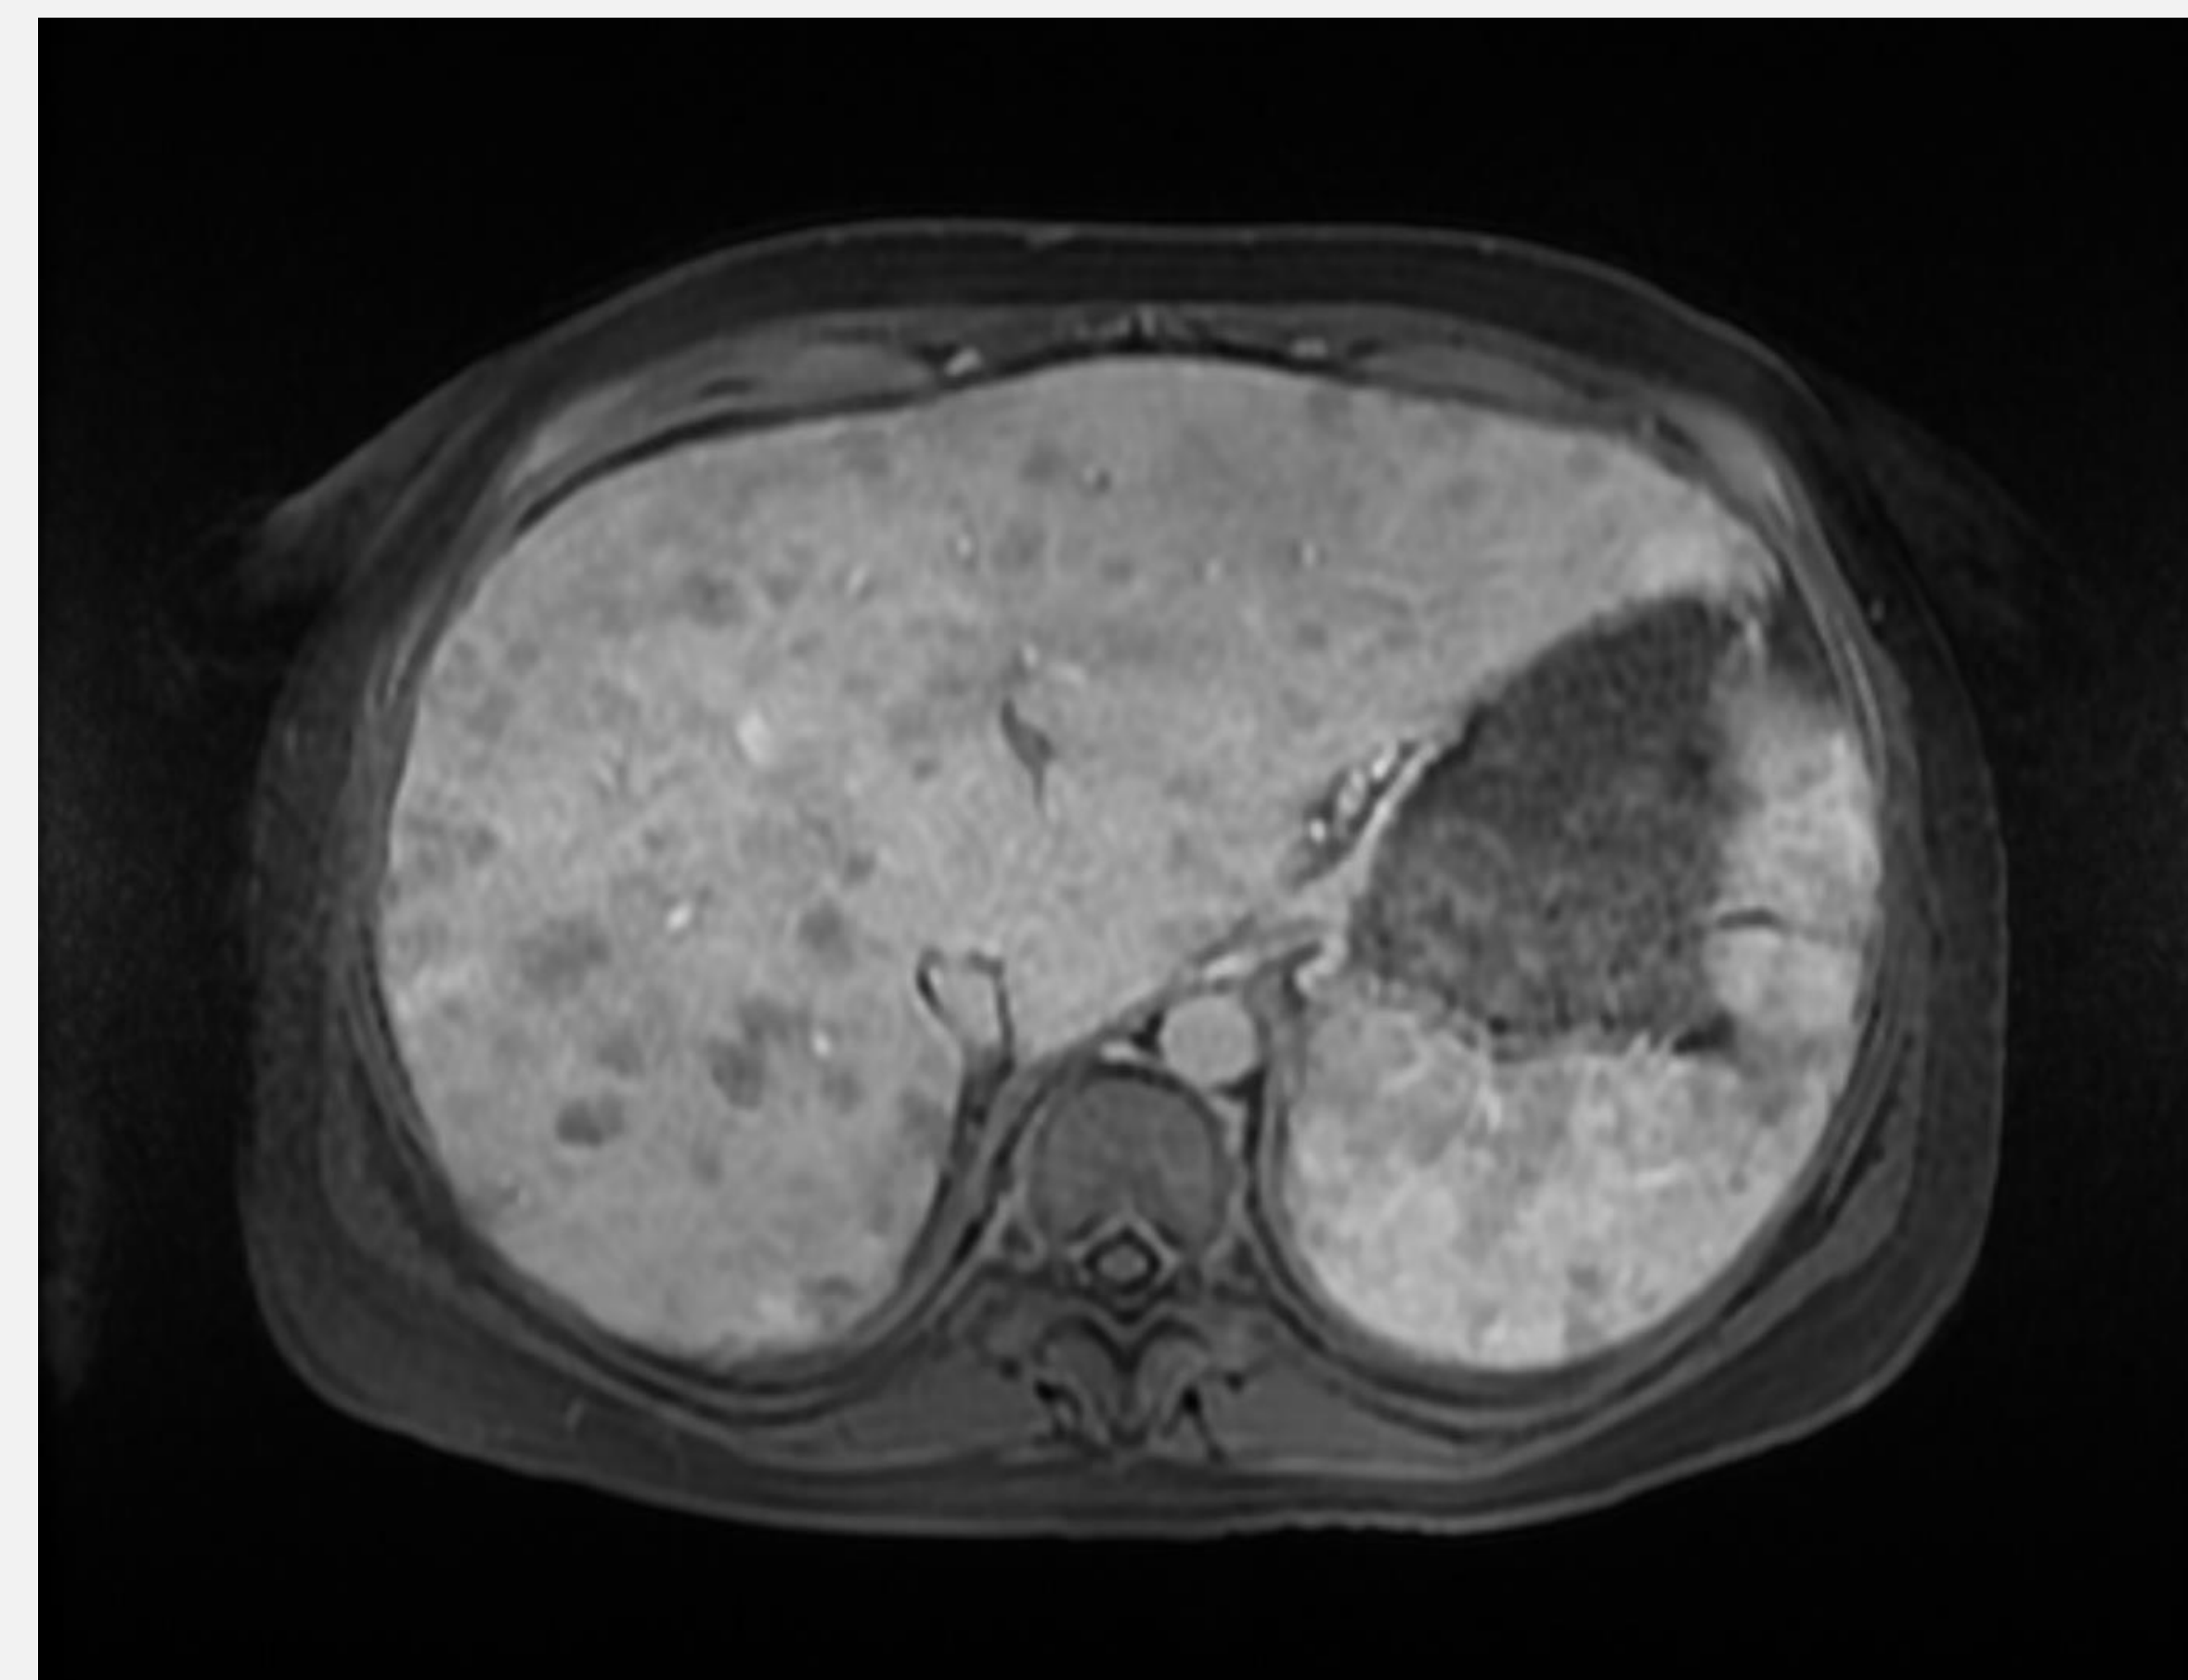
Hypointense liver lesions on MRI, initially presumed suspicious for diffuse hepatic metastatic disease, later confirmed to be sarcoid lesions
